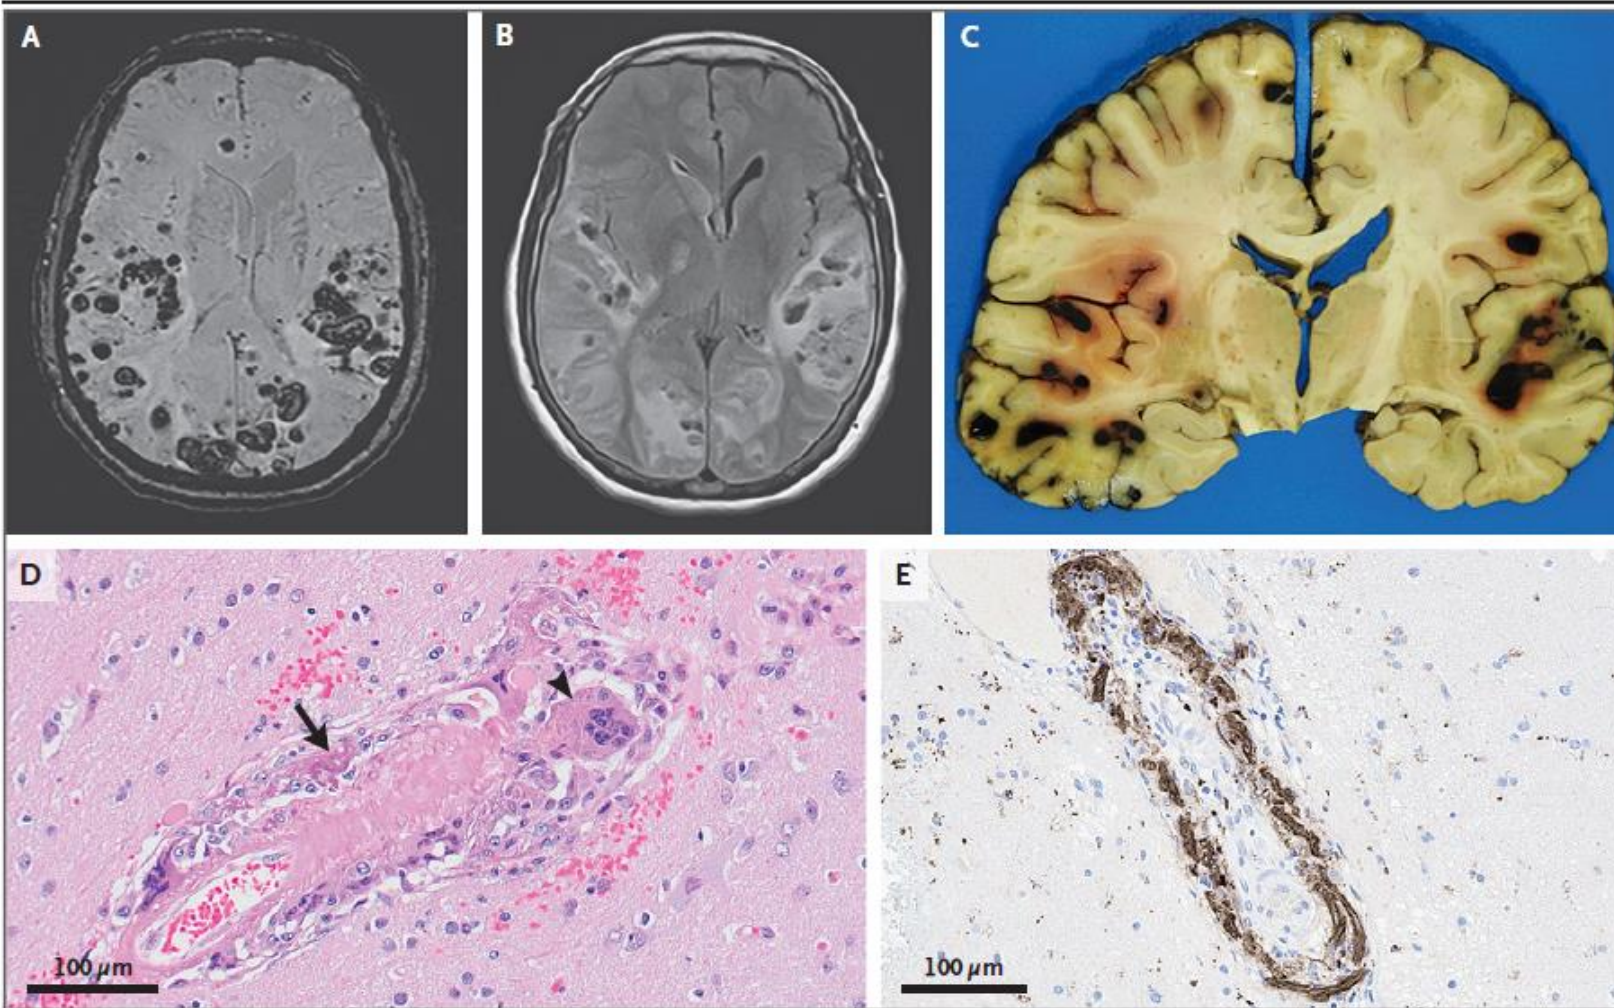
MRI and Neuropathological Findings.
